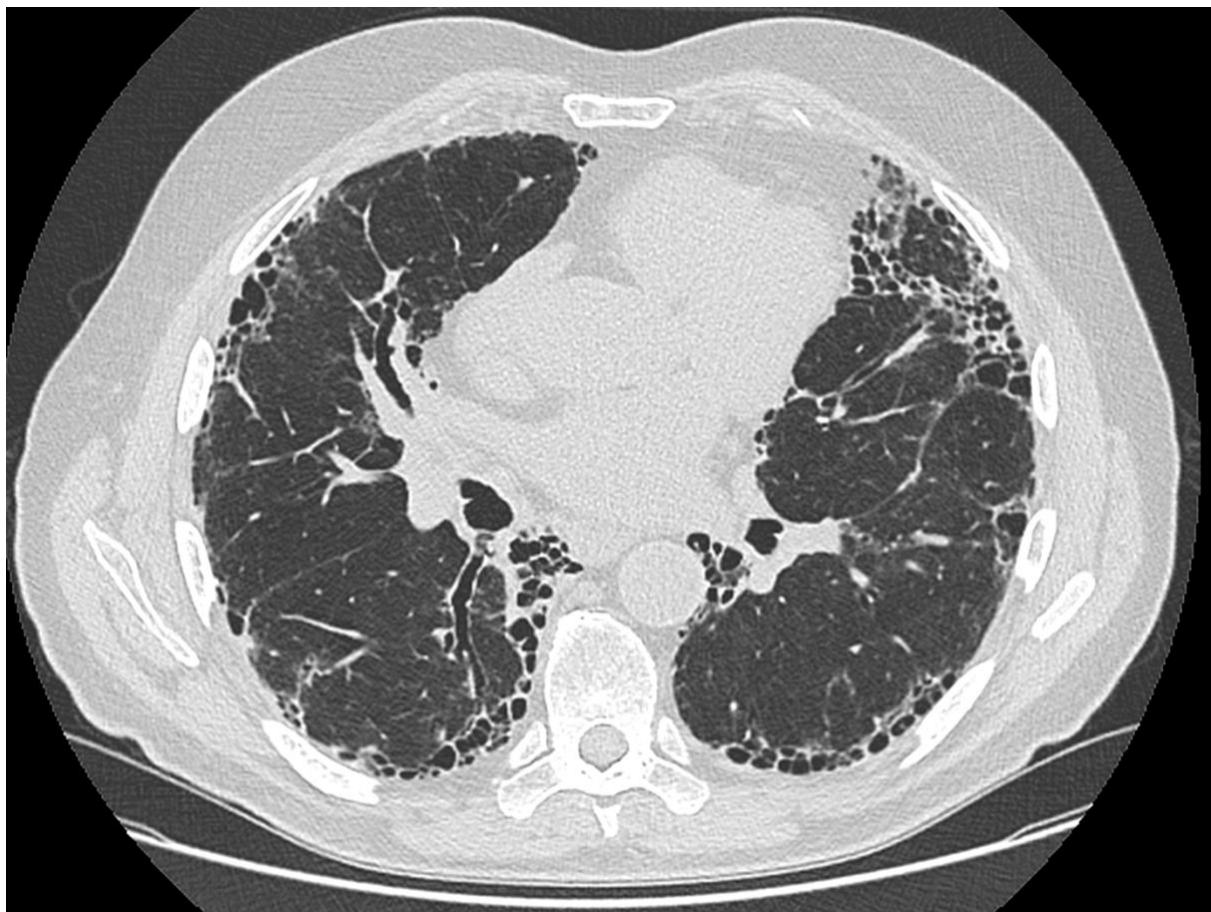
Definite UIP pattern on HRCT showing subpleural fibrosis, honeycombing and traction bronchiectasis. UIP: usual interstitial pneumonia, HRCT: high resolution computed tomography
